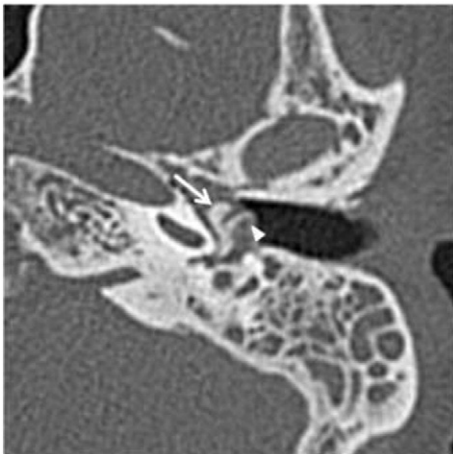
Axial CT image of the left temporal bone showing abnormal dense bone formation (arrows) which is adjacent but separate from the malleus handle (arrowhead).
